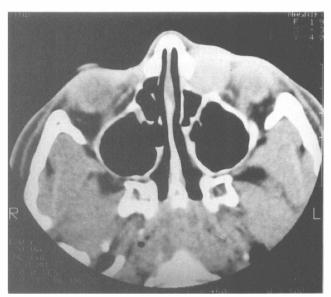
CT scan showing lesion in left medial canthal region.
